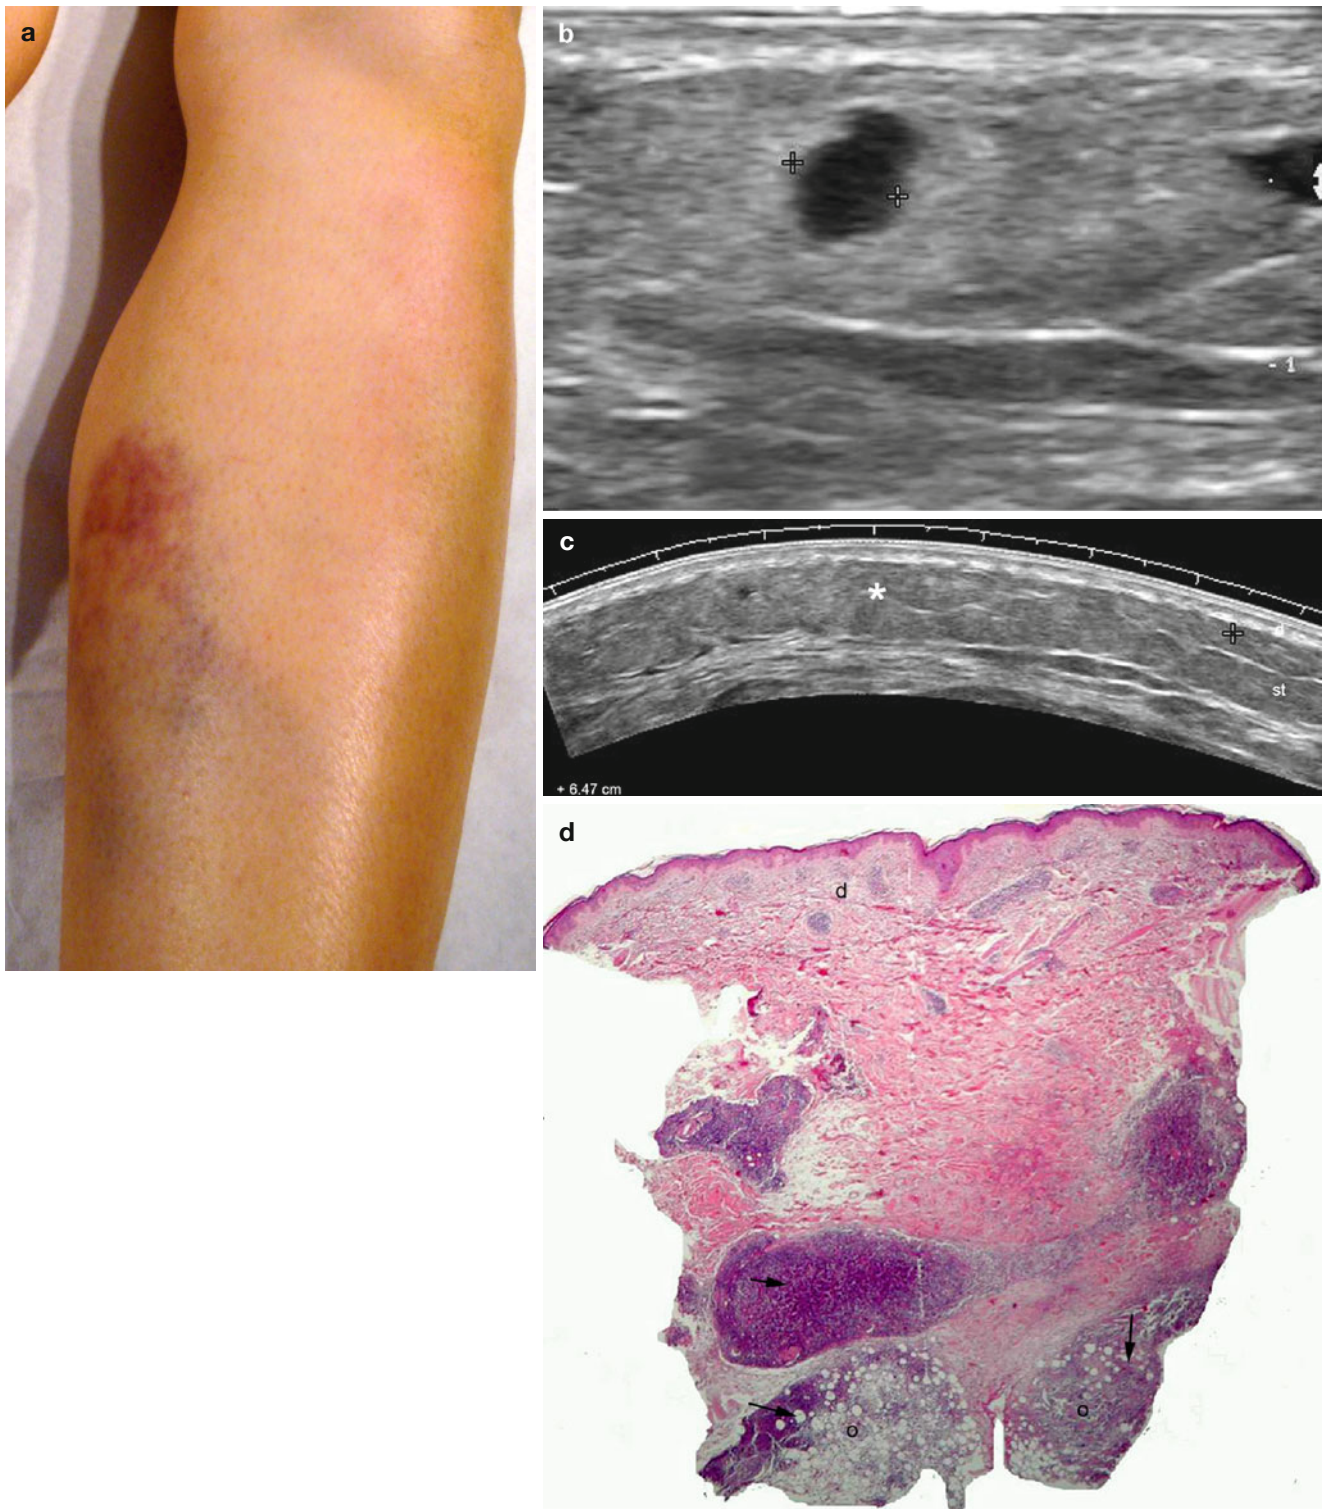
(a–d) Mostly lobular panniculitis secondary to insect bite. (a) Clinical lesion shows erythema and echymosis in the site of the bite (spider). (b) Gray scale ultrasound image (longitudinal view) demonstrates increased echogenicity of the subcutaneous tissue and a round-shaped anechoic pseudocystic structure (between markers) that corresponds to fat liquefaction (fat necrosis). (c) Gray scale ultrasound
